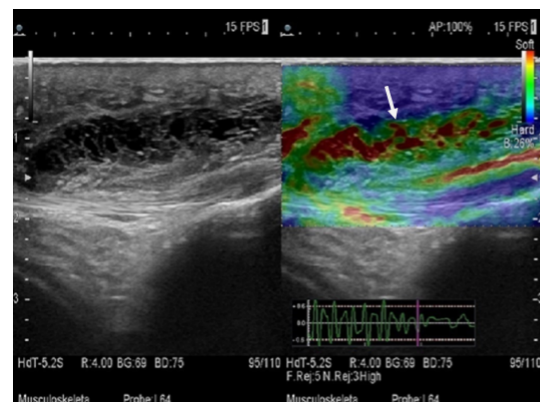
Patient with a history of fall on knee presented with a swelling. On sonography a multiseptate hypochoic lesion with thin septation seen suggestive of resolving hematoma. Elastography shows typical BGR appearance of cystic lesion (white arrow).
